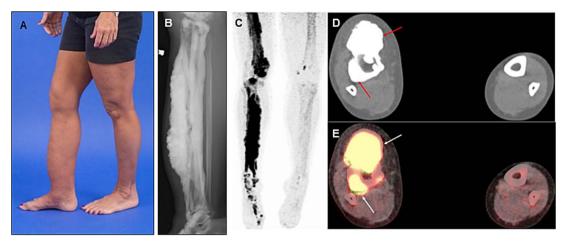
Clinical and radiographic appearance of classical melorheostosis. (A) Clinical photograph showing limb enlargement. (B) Lateral radiograph of the tibia shows flowing hyperostosis. (C) and (D) Increased uptake is seen in 18F-sodium fluoride PET scan. From Kang et al.,⁷ used by permission.
